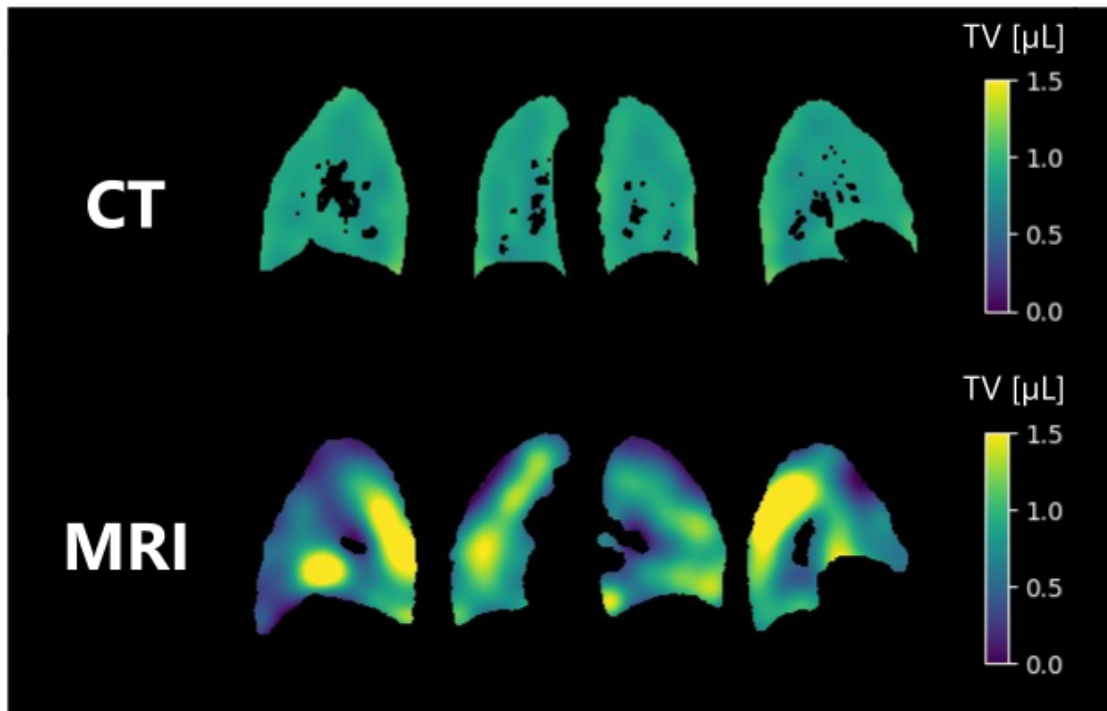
Local tidal volumes (TV) computed for a healthy volunteer lying in the supine position between end-of-expiration and end-of-inspiration for CT acquisitions (top) and MRI acquisition (bottom). The lung structure was segmented, and the main vessels (black holes) were removed. The global tidal volume was 1.17 L on CT and 0.89 L on MR acquisitions using k-means-based segmentations for both respiratory phases. Functional lung MRI reveals highly inhomogeneous patterns compared to CT, as some lung regions are not solicited. It might be explained by the difference in respiration for the two acquisitions that were not controlled: breath-hold for CT and free-breathing for MRI.
